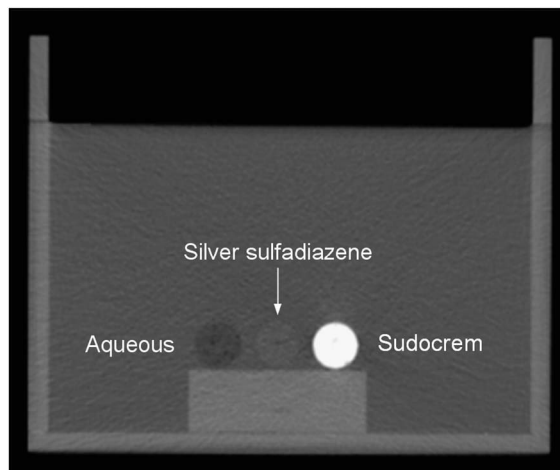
Computed tomography image showing radiodensity of all three creams in single scan.
